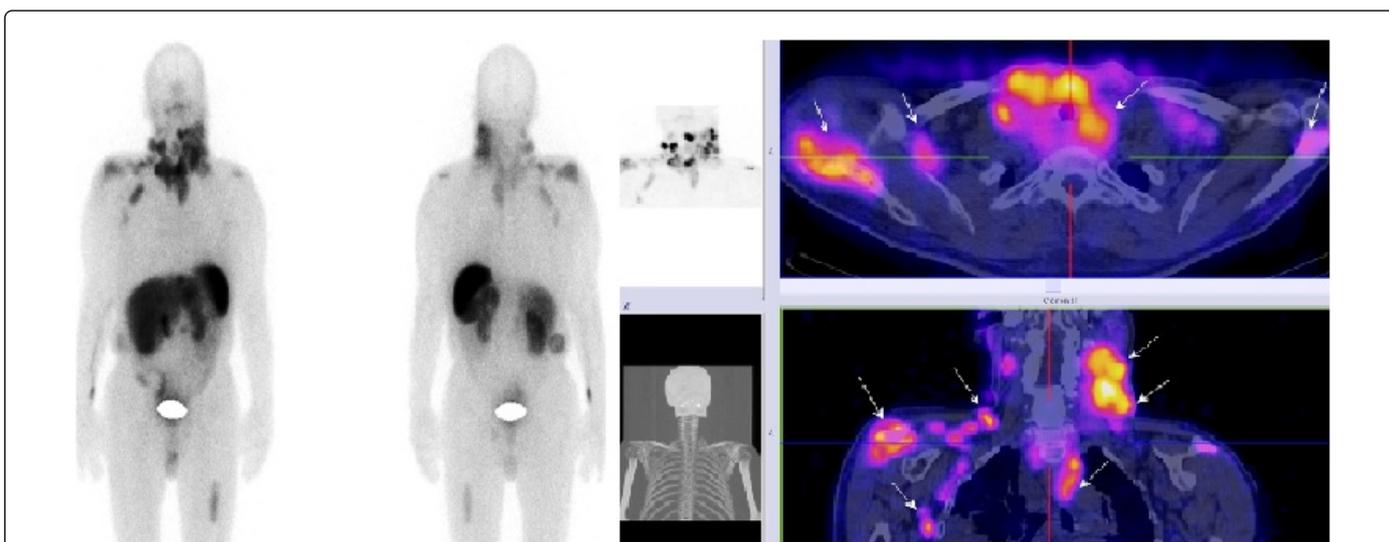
M/68year-old with MTC after total thyroidectomy and cervical lymph node dissection- pT3pN1aM0. Disease recurrence with Calcitonin-56000 pg/ml in December 2014. Whole-body scan followed by SPECT-CT with $^{99\text{m}}\text{Tc}$ -Tektrotyd showed exact topographic disease extension in the region of the thyroid bed, bilateral laterocervical, left paratracheal, mediastinal and supraclavicular bilateral enlarged lymph nodes, bone metastasis in bilateral shoulder joints, left femur, in retroperitoneal region with infiltration of right kidney, subcutaneous lesions, liver metastases were imaged with high tracer uptake.
